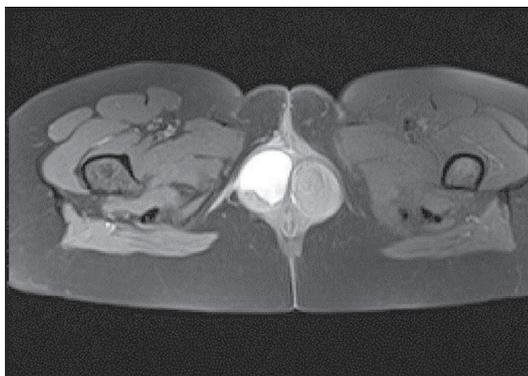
The MRI study revealed the presence of two heterogeneous, hyperintense in T1 hematomas.
